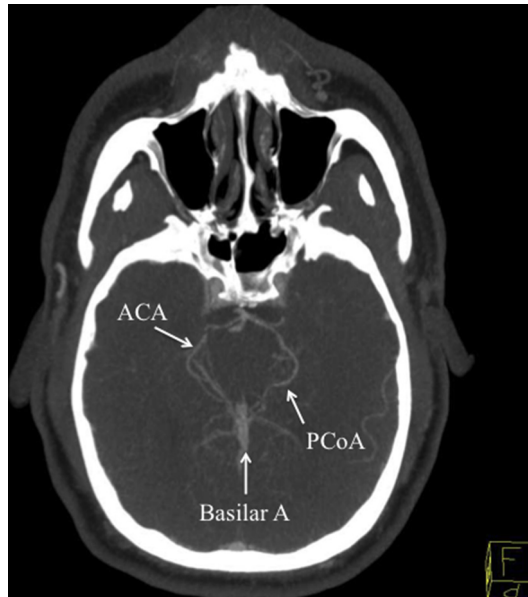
Computed tomography angiography of the head showing normal anatomy of the circle of Willis without cerebral artery aneurysm in a 36 year old with coarctation of the aorta. Given that hypertension may play a role in the growth of intracranial aneurysm, these patients should be monitored and treated if indicated. ACA, anterior cerebral artery; basilar A, basilar artery; PCoA, posterior communicating artery.
